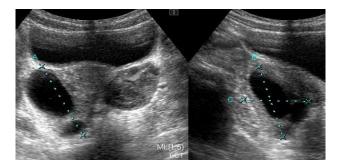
Follow up ultrasonography showing reduced size of bilalateral ovarian cysts.
